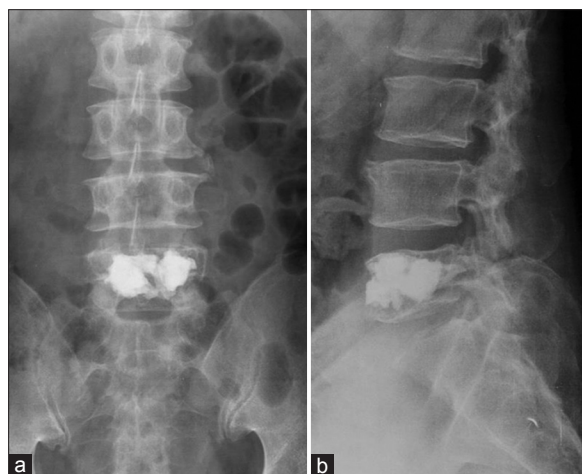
Antero-posterior (a) and lateral (b) X-rays show the polymethylmethacrylate augmentation of the L5 vertebral body after bipoportal balloon kyphoplasty
